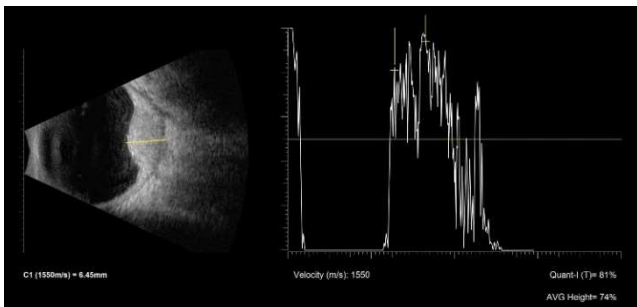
B and A-scan ultrasonography were repeated, revealing a nodular hyperechogenic lesion associated with scleral thickening and medium to high reflectivity, respectively.
